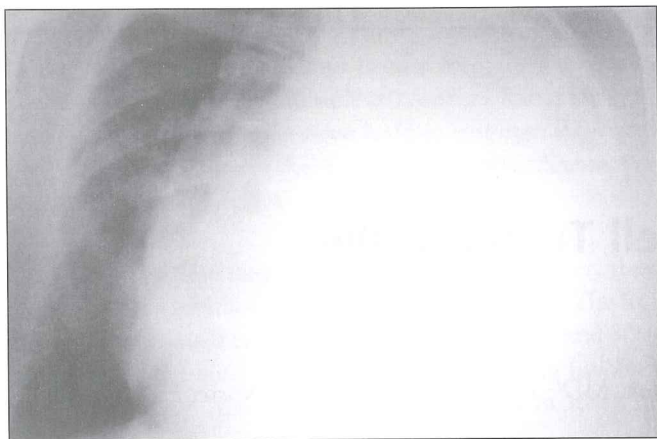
Postero-anterior chest X-ray showing a homogenous opacity on the left hemithorax and deviation of the trachea and mediastinum to the right.
